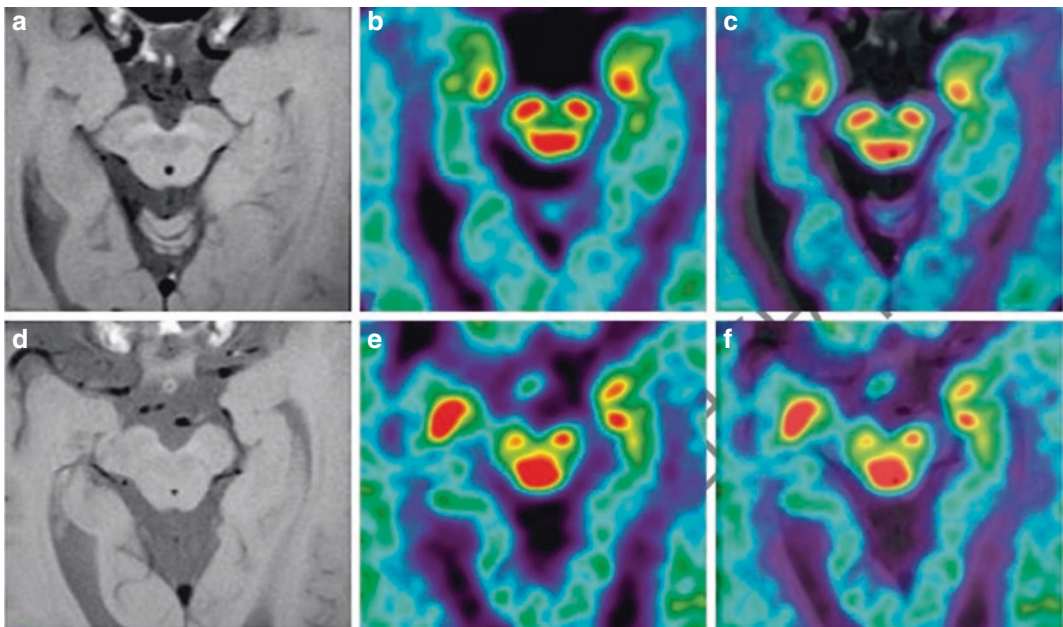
Integrated ^{18}F -AV133 PET/neuromelanin-sensitive MRI of healthy subjects and patients with PD. Healthy subjects (a–c); patients with PD (d–f). In healthy subjects, transverse neuromelanin-sensitive MRI (NM-MRI) shows normal neuromelanin hyperintensities in the bilateral substantia nigra, with no signal decrease or morphological changes (a); transverse ^{18}F -AV133 PET imaging (b), and fused ^{18}F -AV133 PET/MR (c) show
